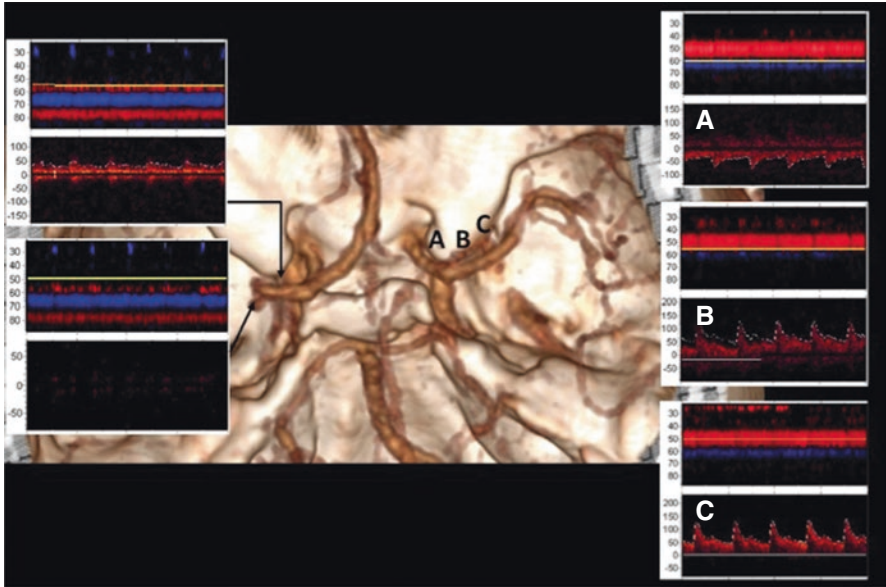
Correlation between angio-TC and TCD. Absence of flow signal at 50 mm depth on the left side. Asymmetry between flow velocities in both MCAs and a smaller representation in mode M of the occluded side. On the right side, normal sonograms are presented (A: Corresponds to segment A1 of the anterior cerebral artery. B: Middle cerebral artery near the bifurcation. C: Middle cerebral sonogram near segment M2)
